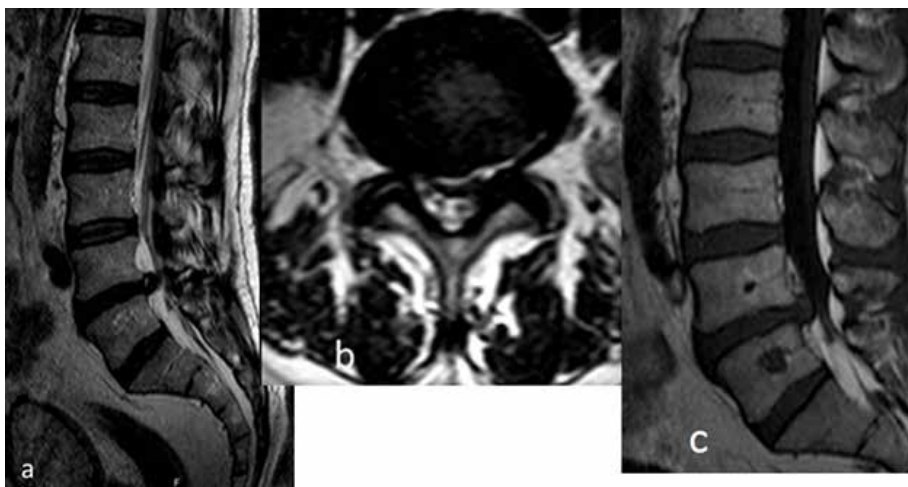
A lesion mimicking lumbar disc herniation and annular defect was seen on the T2-weighted sagittal (a), T2-weighted axial (b), and T1 weighted sagittal (c) MRI sections 6 months after percutaneous hydrogel implantation. It was noted that the lesion was hyperintense on T2-weighted and hypointense on T1-weighted MRI section.
